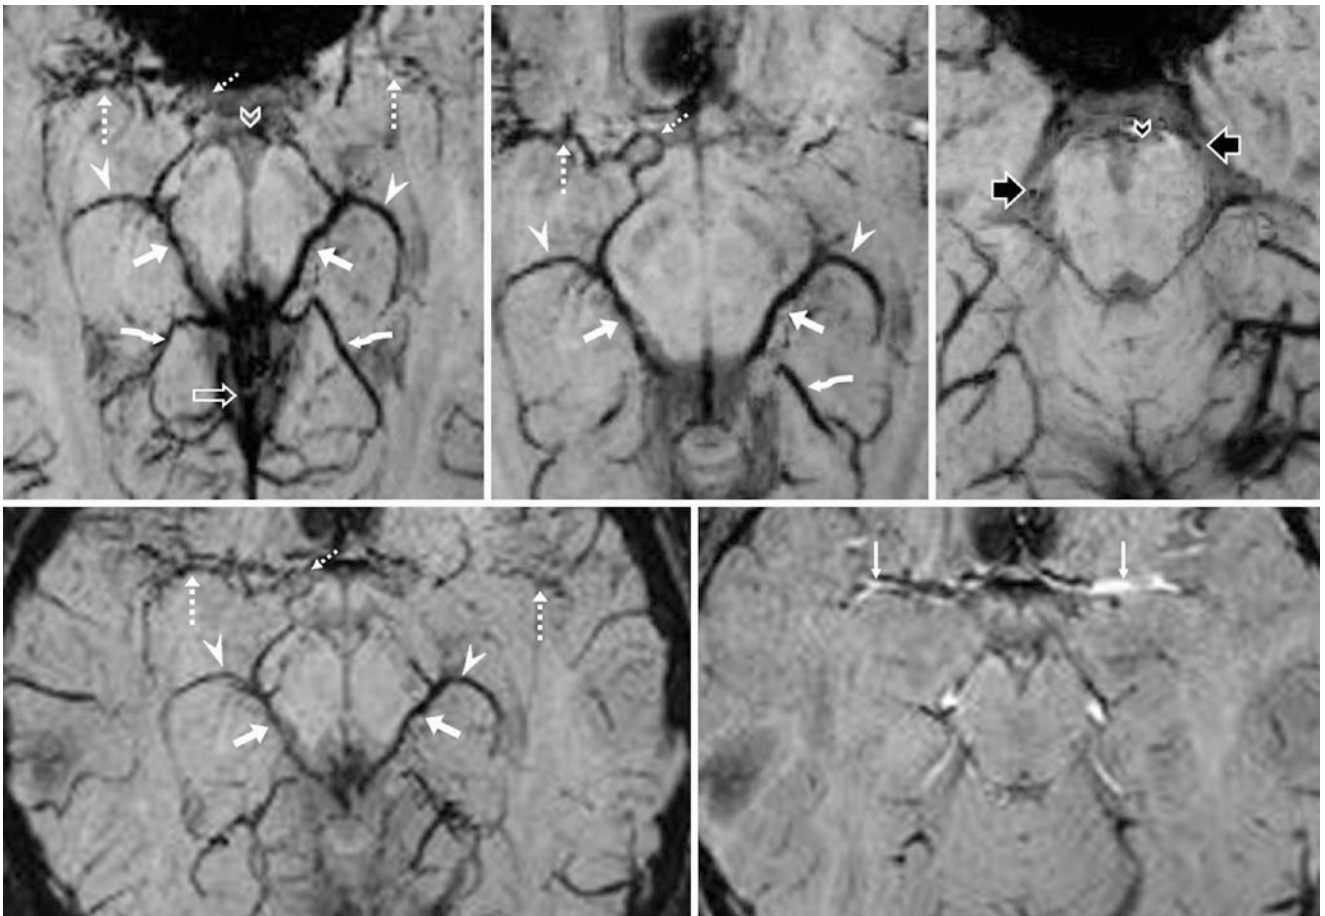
3T MRI in a 7-year-old depicts the BVRs (*short arrows*), deep MCVs (*dotted arrows*), IVVs (*arrowheads*), IOVs (*curved arrows*), uncal veins (*thin dotted arrows*), and VOG (*open arrows*) on SWI at thicknesses of 17 mm (*top left*), 7 mm (*top middle and right, bottom left*) and 1.5 mm (*bottom right*). Note the lateral mesencephalic
